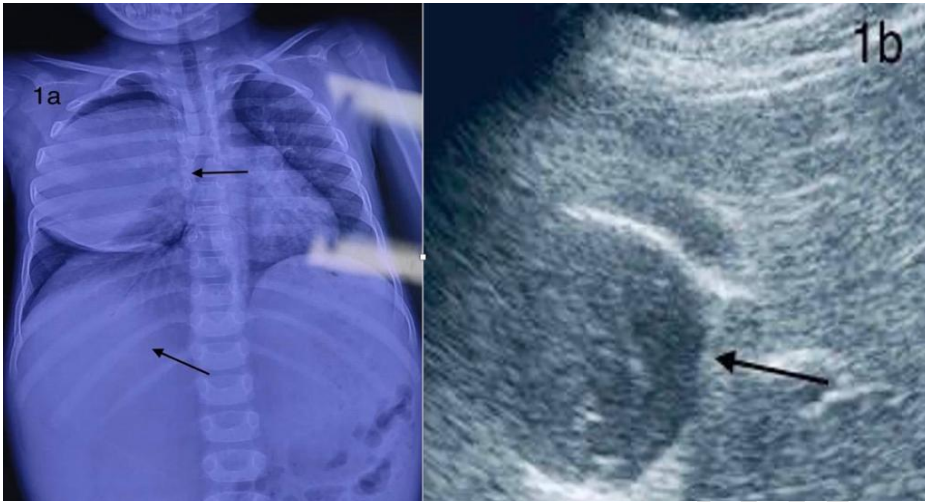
Chest X-ray revealed a large dense round well demarcated opacity involving the right lung field and opaque homogenous zone of cyst in right upper abdomen (marked by arrows), 1b. Ultrasound abdomen revealed well defined unilocular cystic lesion with internal echoes and no internal septations (marked by arrow)
